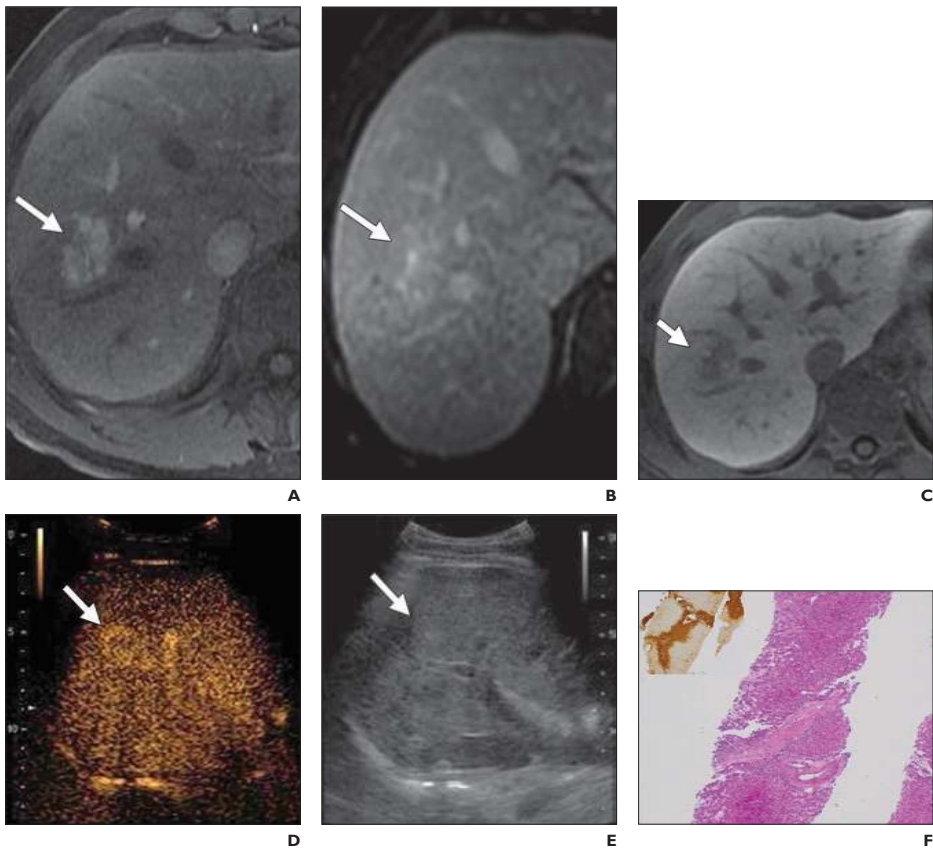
24-year-old man with focal liver lesion who underwent contrast-enhanced sonography and MRI performed with liver-specific contrast agent; findings were discordant for focal nodular hyperplasia (FNH).
